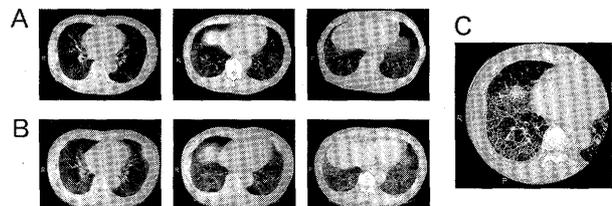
(A) Chest CT scan shows bilateral honey-comb lung before leuporelin acetate administration in August 2000. (B) Chest CT scan shows bilateral lung exacerbation induced by leuporelin acetate. A metastatic lesion appeared on the left-sided chest wall in May 2002. (C) HRCT scan apparently shows honey-comb lung
